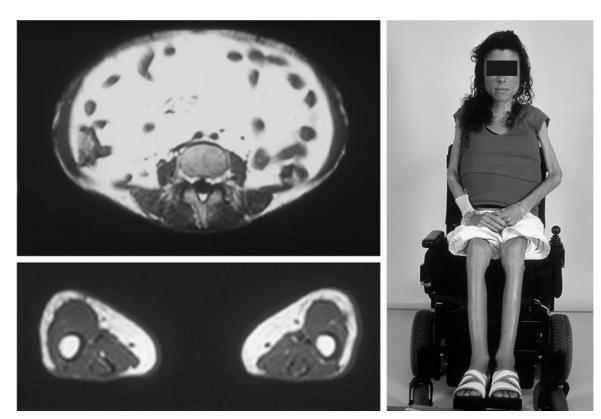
A case with severe juvenile dermatomyositis and generalized lipodystrophy. The physical appearance of the 19-year old patient is presented (right). She has severe loss of both muscle and fat tissue. T1-weighted magnetic resonance images of the patient are also presented (left). Transverse sections of the torso at the level of the fifth lumbar vertebra demonstrate markedly deficient subcutaneous and markedly increased visceral fat (top). Transverse sections of the midthigh demonstrate asymmetrical absence of subcutaneous fat with preservation of medial subcutaneous fat and marrow fat (bottom).
